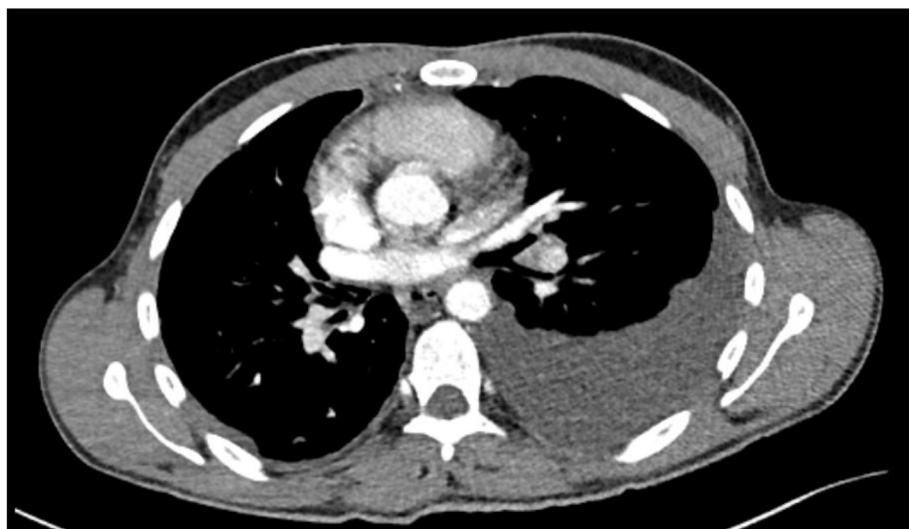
CT angiogram with PE protocol demonstrating large left pleural effusion at time of COVID-19 pneumonia diagnosis.
